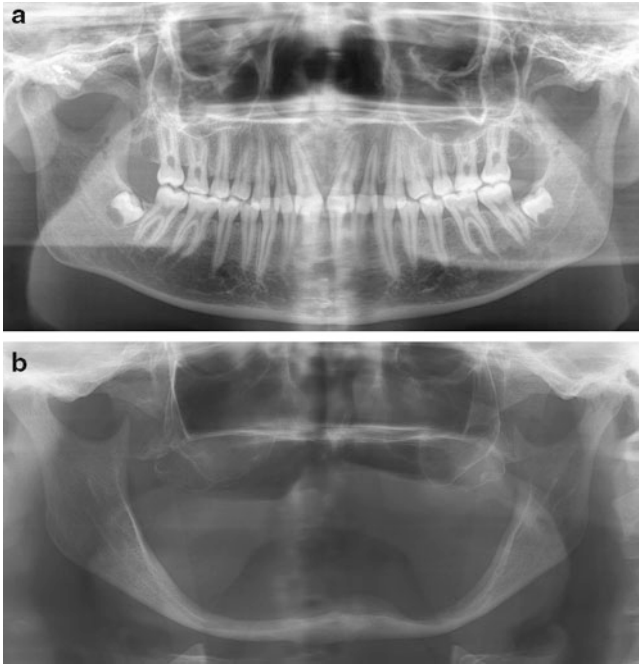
Radiograph of fully dentate jaws with no signs of bone loss or other defects (a). Advanced resorption of the mandible in an edentulous patient (b)
